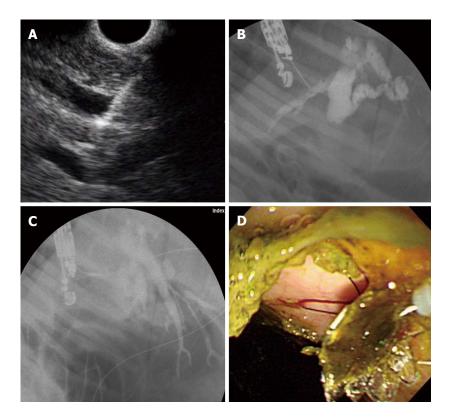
Endoscopic ultrasound-guided hepaticoenterostomy. A: Linear endoscopic ultrasound (EUS) image shows a 19-G needle puncture targeting the intrahepatic bile duct (IHD; B: Fluoroscopic image reveals marked IHD and common bile duct dilatation with ampullary obstruction; C: After EUS-guided 19-G needle puncture of the IHD, the device for one-step endoscopic ultrasound-guided biliary drainage system was inserted and the stent released under the guidance of EUS and fluoroscopy; D: Following successful deployment of the stent, the bile passage was seen in the high body of stomach.
